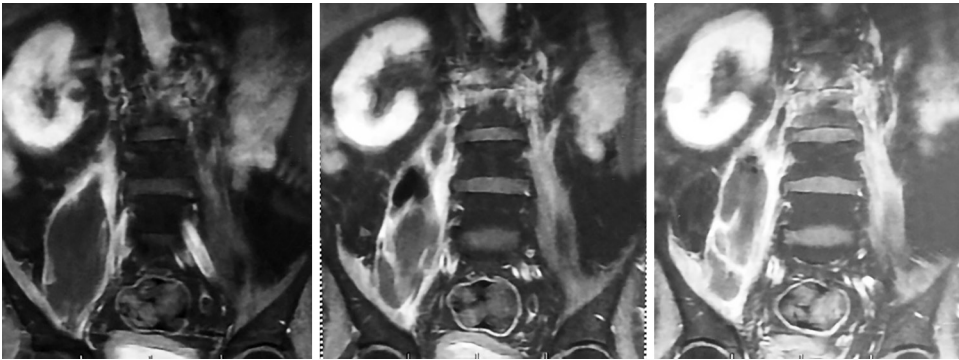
MRI STIR coronal image showing signal alteration in L2-L3 paravertebral region with enhancing lesion in right psoas region.
